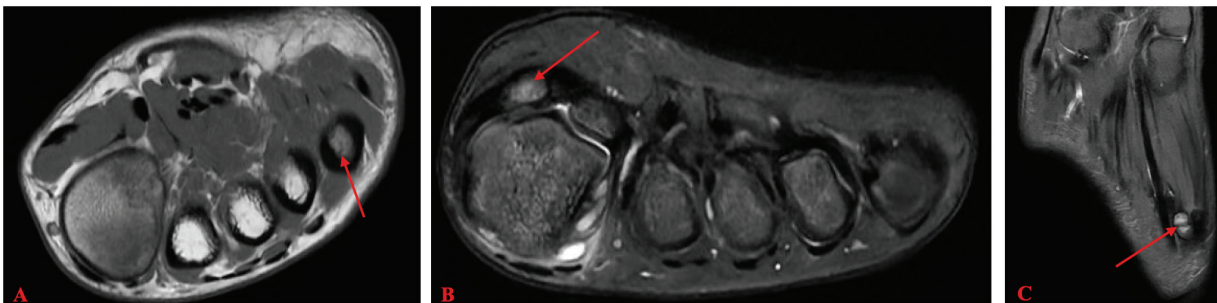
T1 axial MRI showing nondisplaced 5th metatarsal stress fracture (A). Bipartite medial hallux sesamoid with edema of the proximal greater than distal pole raising consideration for sesamoiditis/stress response in T2 axial (B) and T2 coronal (C) MRI images.
